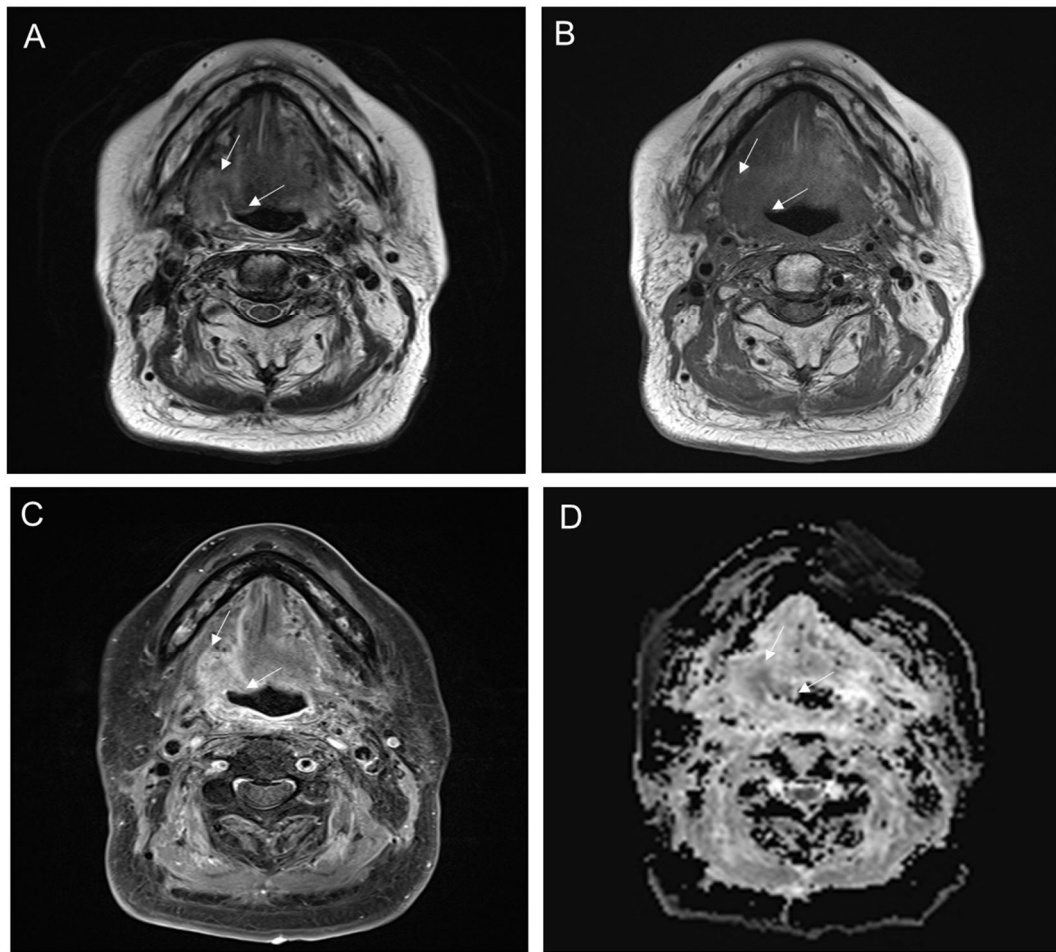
(A-D) Case of tumor recurrence. 85-year-old man with oral cavity (tongue) cancer received operation followed by chemo-radiation therapy. On MRI after 9 years, enhancing lesion was detected in the post-operation site. (A-B) T2WI & T1WI shows ill-defined superficial spreading mass involving right side of tongue base, right lateral oropharyngeal wall. (C) CET1WI shows moderate enhancement of lesion. (D) ADC map shows diffusion restriction of the lesion.
